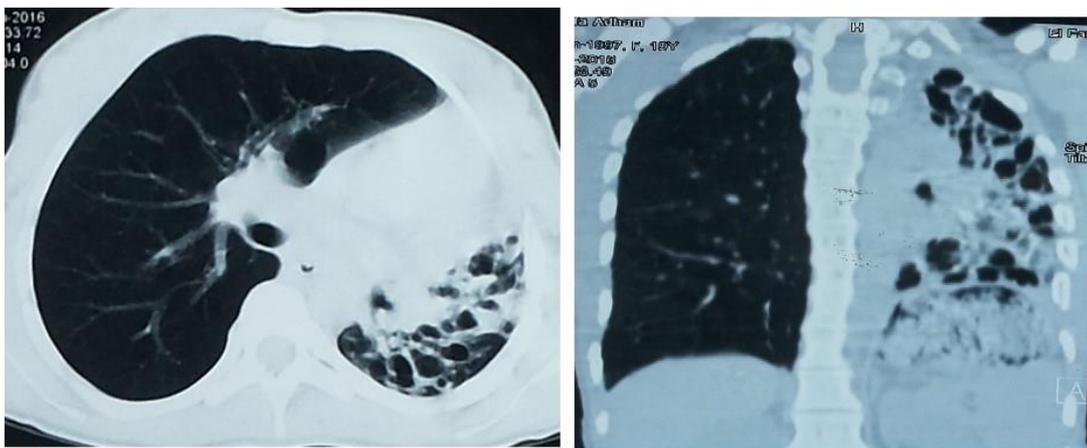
CT chest (axial and coronal views) shows destroyed left lung due to bronchiectasis
